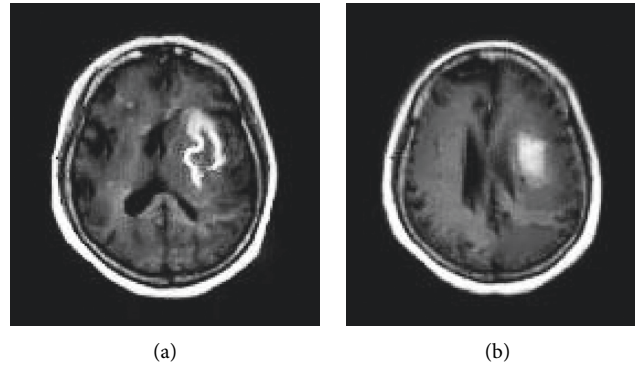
MRI image data of patient. (a) There were irregularly shaped near-oval high-density shadows in the left corona radiata-basal ganglia region; (b) there were long T1 isometric T2 signals inside the lesion in the left corona radiata-basal ganglia region.
